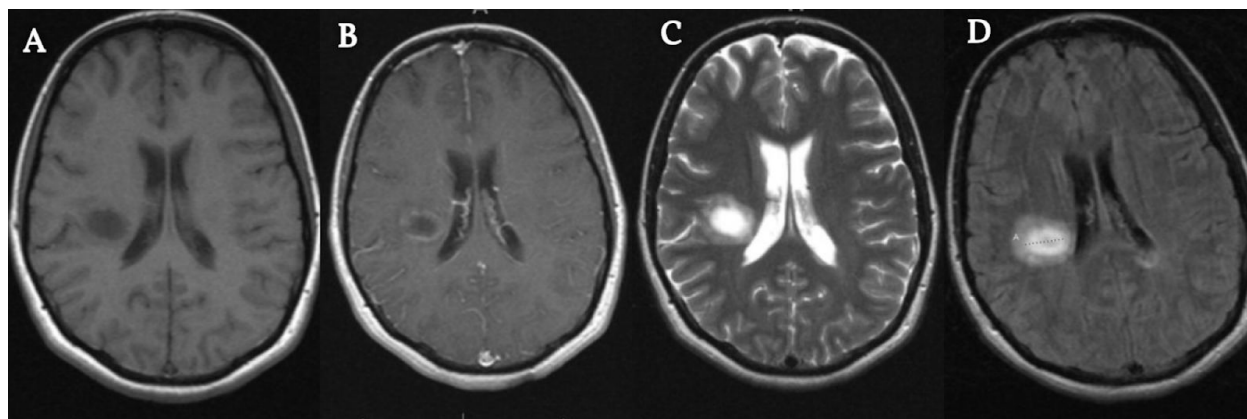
Patient 3 MRI Imaging. (A) T1 Pre Contrast (B) T1 Post Contrast (C) Axial T2 (D) Axial Flair. There is a 2 cm oval lesion within the right posterior frontal lobe. An open-ring enhancement pattern is seen. It demonstrates a central region of intense T2/flair hyperintensity more moderate at the periphery. Centrally it is T1 hypointense.
